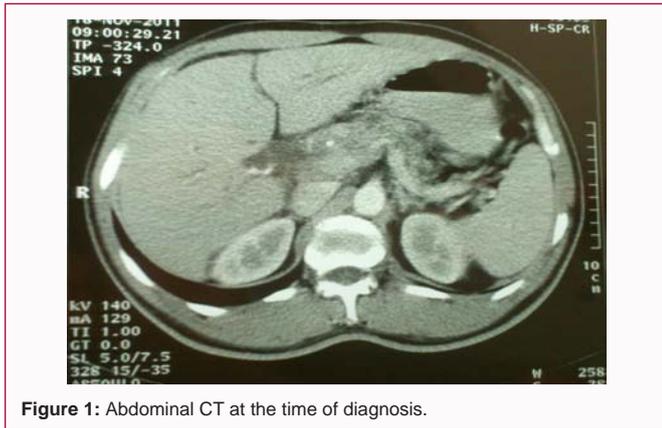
Abdominal CT at the time of diagnosis.
